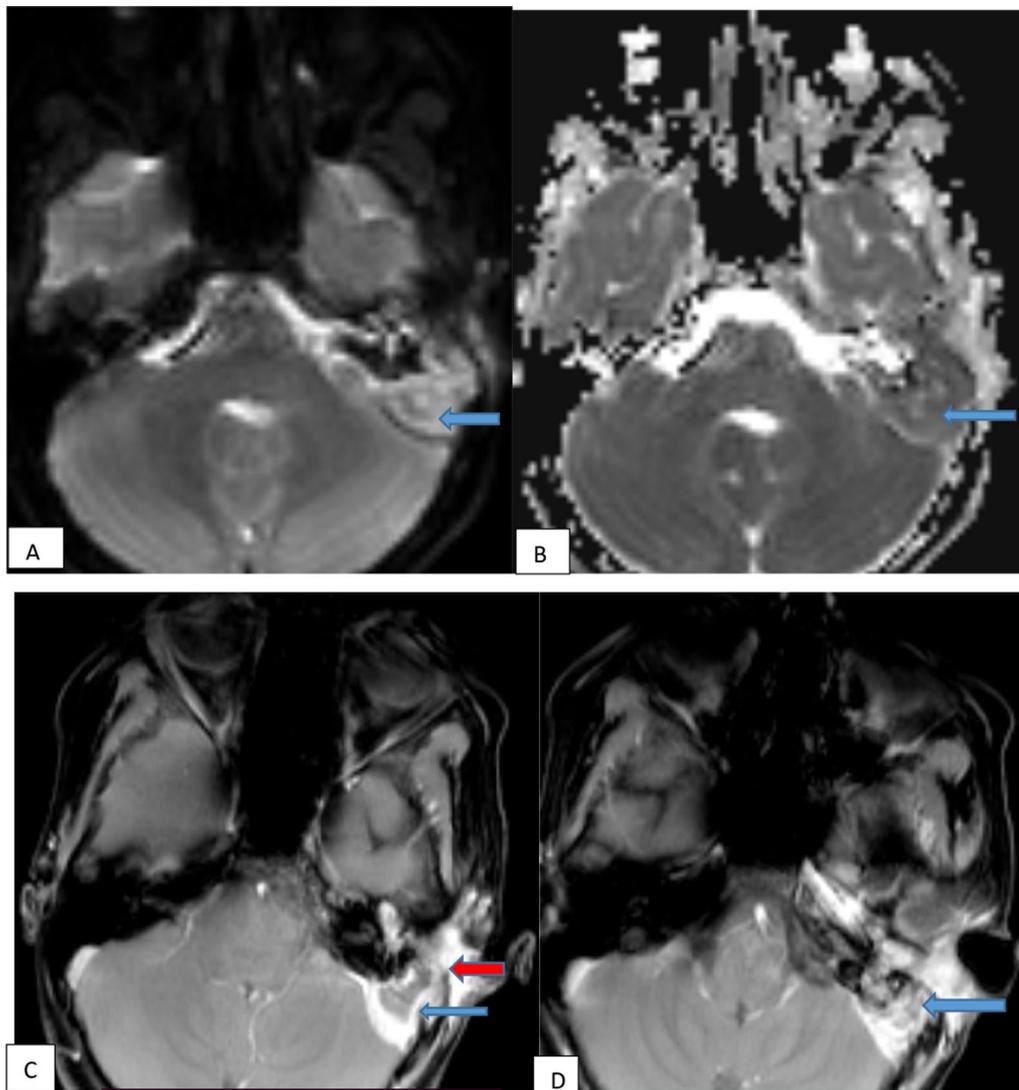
Axial sections of MR image at base of skull shows: A) DWI image: restricted diffusion, predominantly in periphery, in the soft tissue along left cerebellopontine angle (blue arrow). B) ADC image: corresponding signal drop (blue arrow). C) Post-contrast T1 fat-suppressed MR image: Enhancing soft tissue in left external auditory canal, petromastoid air cells (red arrow) with attenuated calibre of left sigmoid sinus (blue arrow). D) Post-contrast T1 fat-suppressed MR image: Markedly attenuated calibre with filling defect within distal sigmoid sinus (blue arrow)
